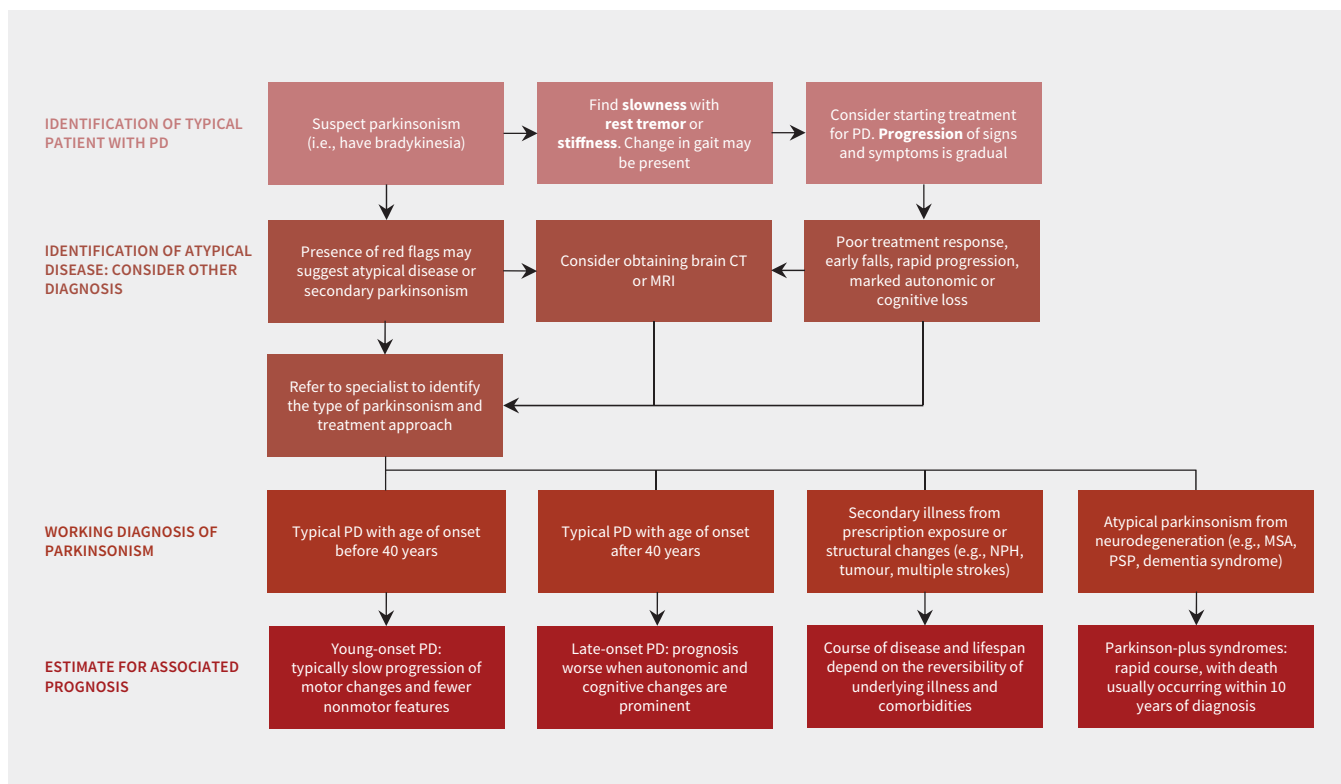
Diagnosis and prognosis of Parkinson disease (PD). Note: CT = computed tomography, MRI = magnetic resonance imaging, MSA = multiple system atrophy, NPH = normal pressure hydrocephalus, PSP = progressive supranuclear palsy.
